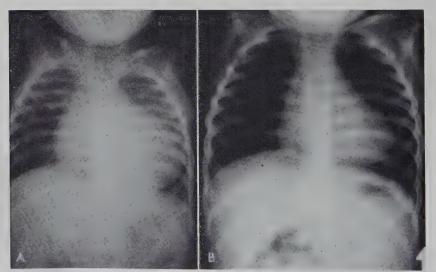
Postero-anterior roentgenograms of chest. A. One-month-old infant with large ventricular septal defect and severe congestive heart failure despite medical treatment. B. Same child two months after banding of pulmonary artery. Heart has descreased in size and pulmonary fields are clear.
